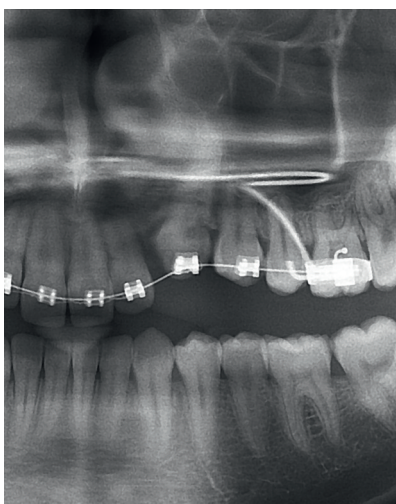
X-ray of a patient with an external resorption on tooth #23 - section from a panoramic X-ray.
